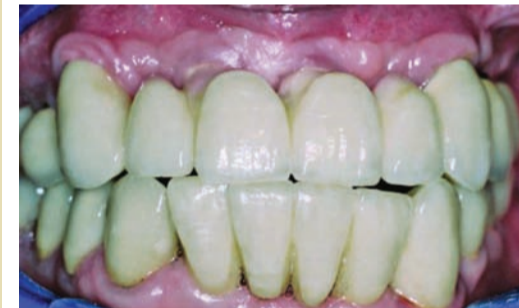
Restauration after initial treatment, before the accident; a) anterior view; b) intraoral view; c) implants with abutments and teeth #13 and #23 with gold copings in place; d) panoramic radiograph
